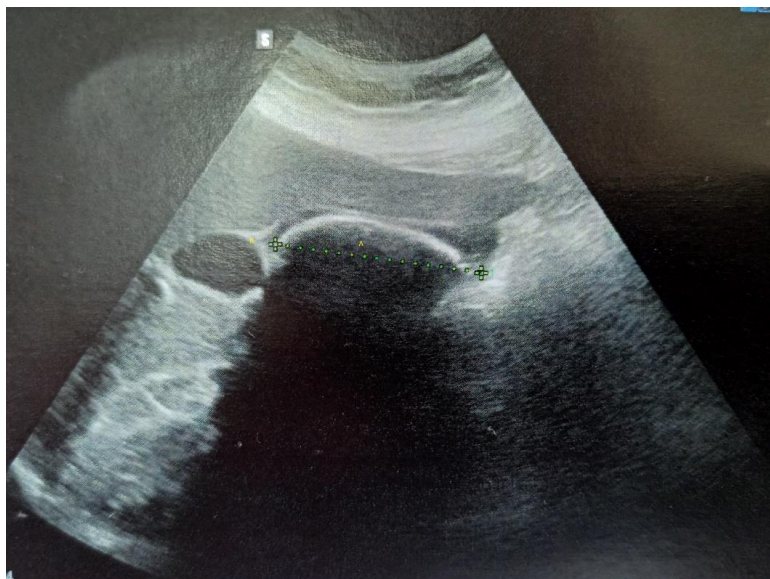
ultrasound image showing :
